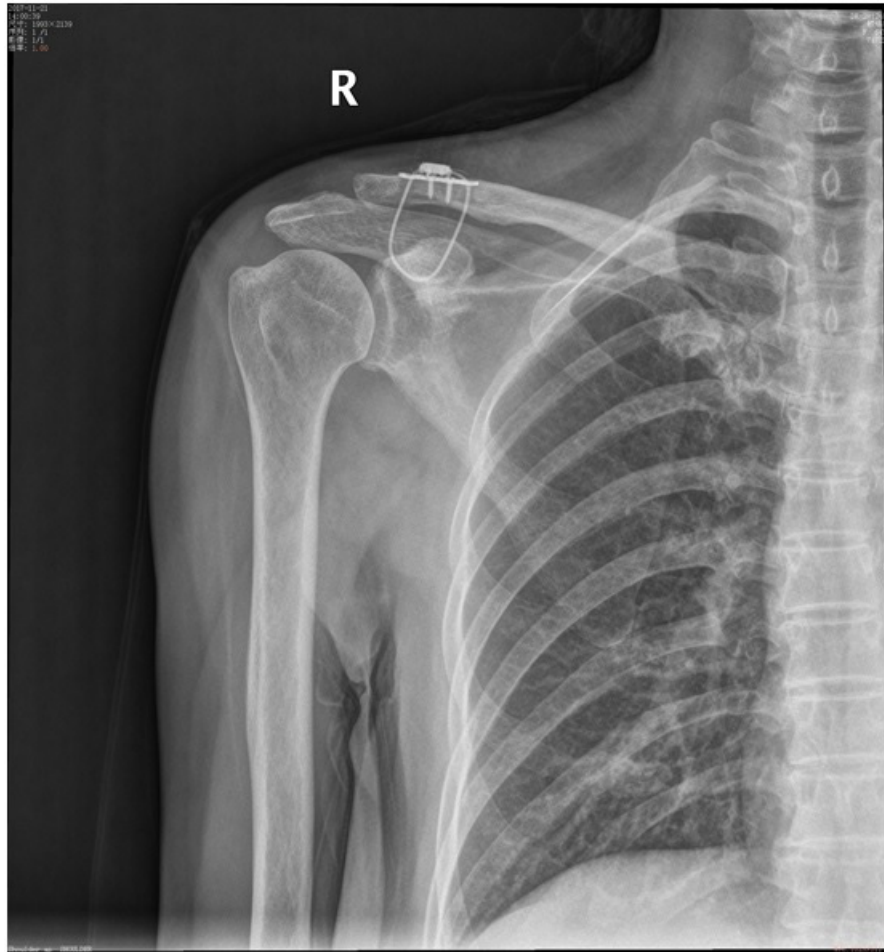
A X-ray in AP view showing a right shoulder in which MSTC combined with AO metacarpal plate was performed.
